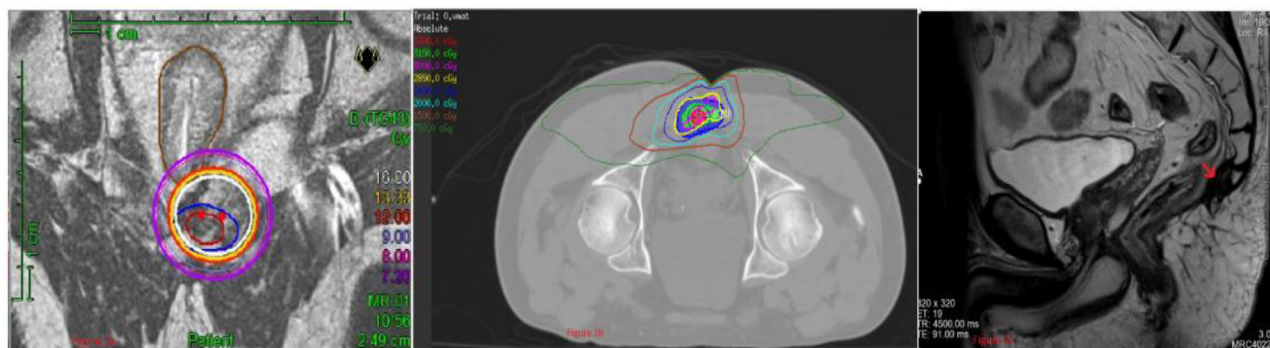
(a) Pelvic magnetic resonance imaging (MRI) scan with catheters in situ showing dose distribution for the recurrent sarcoma with para coccygeal soft tissue deposit (case 3). (b) External beam radiation therapy dose distribution (patient in prone position). (c) Posttreatment resolution of the para coccygeal soft tissue sarcoma (red arrow).
